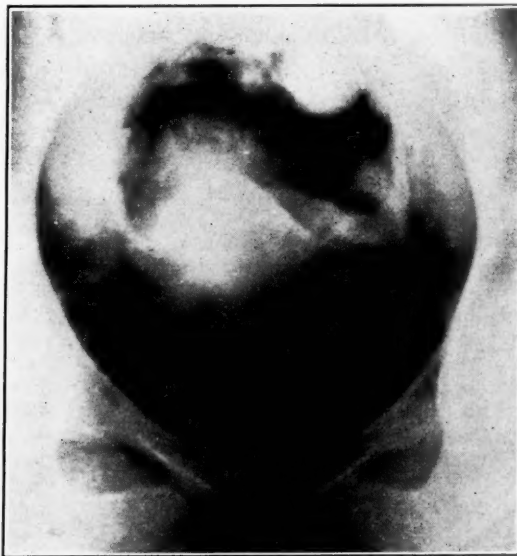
Pelvic roentgenogram by transabdominal pneumoperitoneum showing uterine mass with a more opaque core (hematometra).
